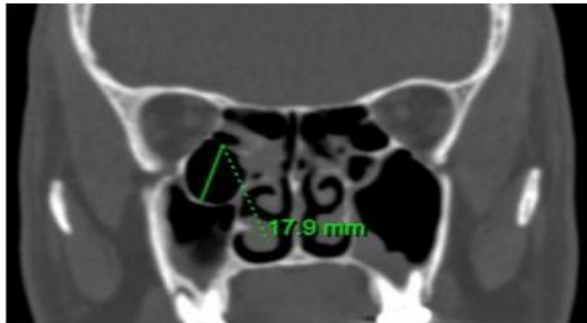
Coronal section of CT-PNS demonstrating large right haller cell obliterating right OMC.
